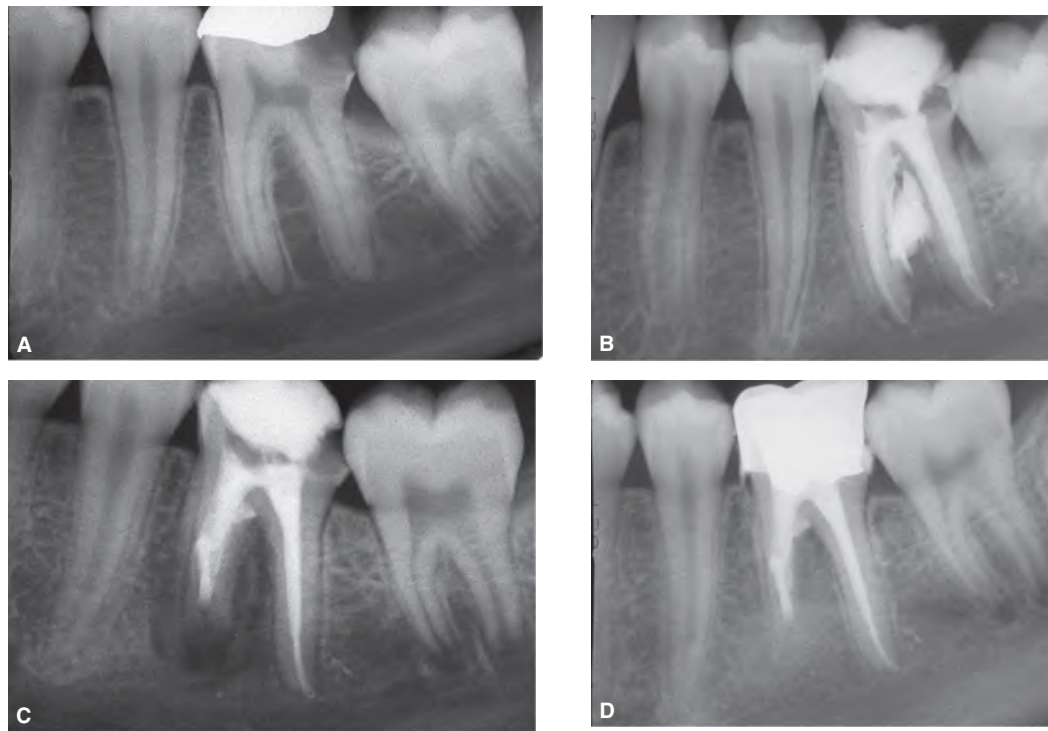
A.* A preoperative radiograph of the first mandibular molar shows presence of a thin distal walls of the mesial roots. *B.* A severe strip perforation occurs during cleaning and shaping of the root canals along with extrusion of root canal filling materials into the periapical tissues. *C.* The perforation was repaired with MTA. *D.* A radiograph taken one year later shows healing of the repaired area.
